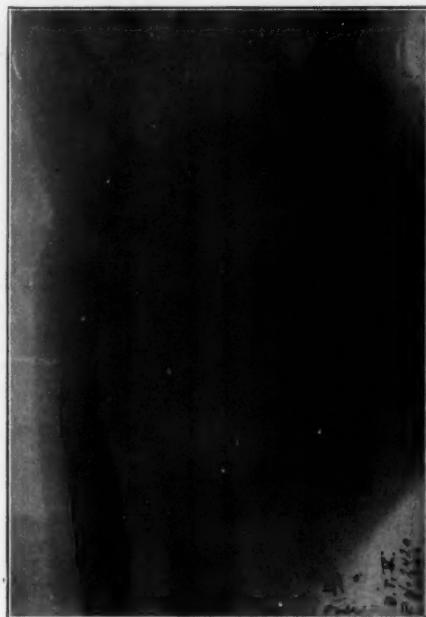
Path. No. 2420 (V). X-ray of giant-cell tumor of lower end of radius with complete destruction of bone shell. See Figs. 42 and 43. Page 185.
